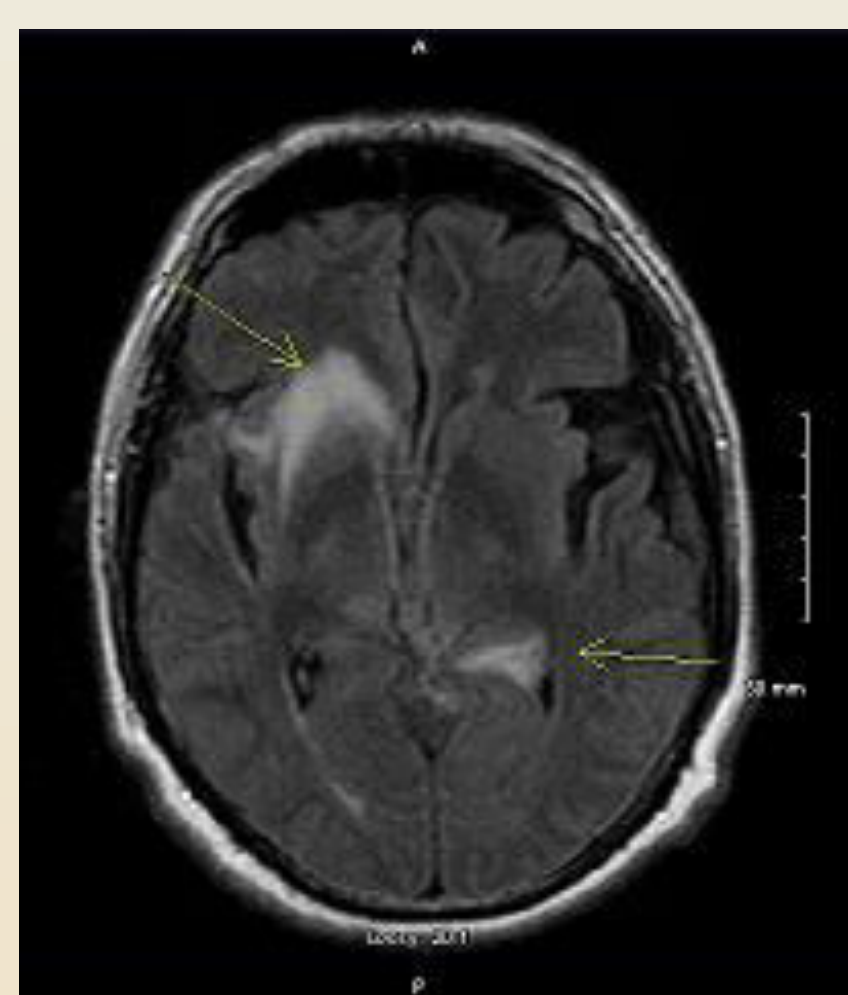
Flair MRI showing abnormal enhancing lesions right frontal lobe and left tentorium. 2012
